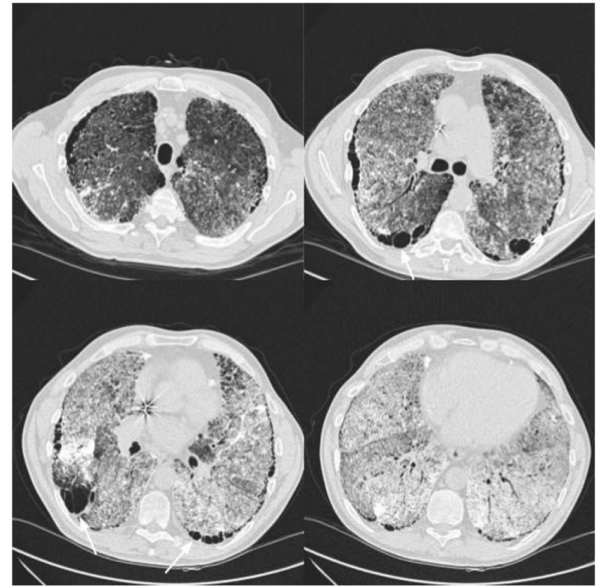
HRCT scan showing diffuse microcalcifications. The apical to basal gradient common in PAM is here clearly visible. Arrows indicate subpleural cysts i.e., the “black pleura sign.”
